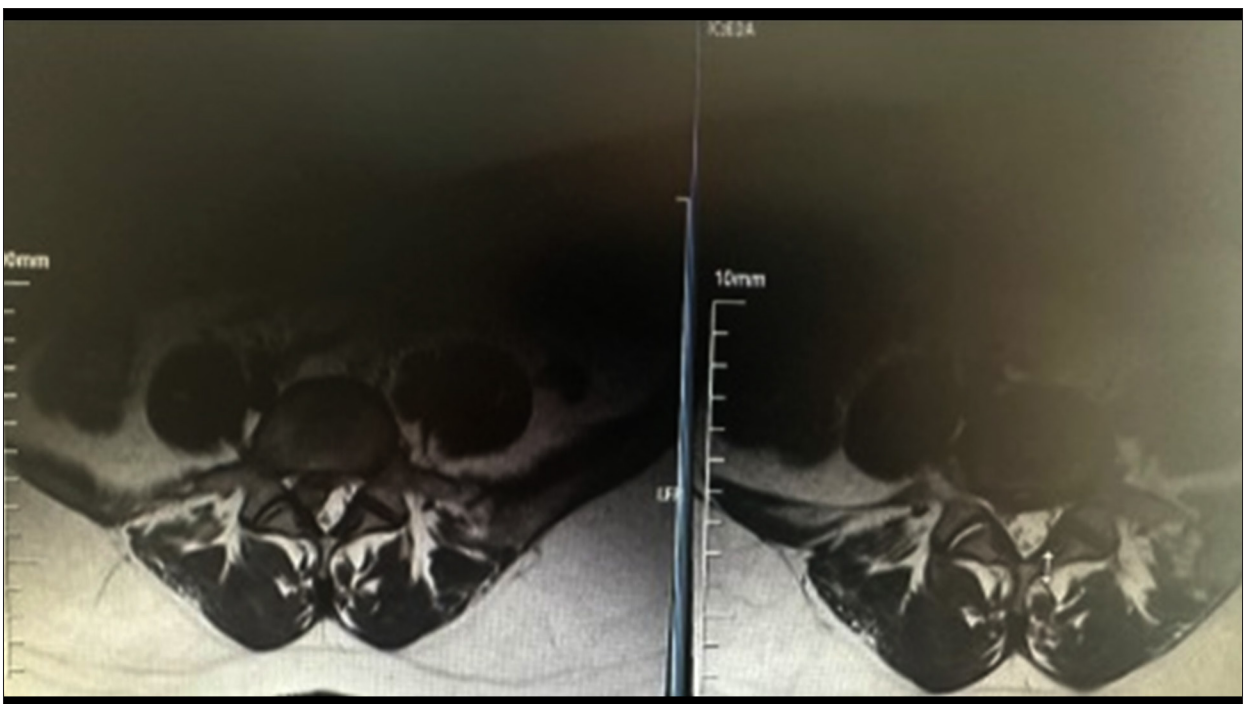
Preoperative/Postoperative 2- month T2 sagittal MRI.
